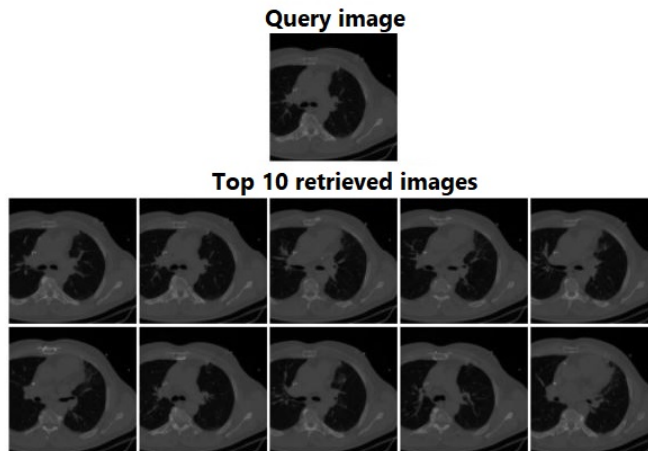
Retrieved images for a NEMA-CT dataset query using RbQE with VGG-19.
